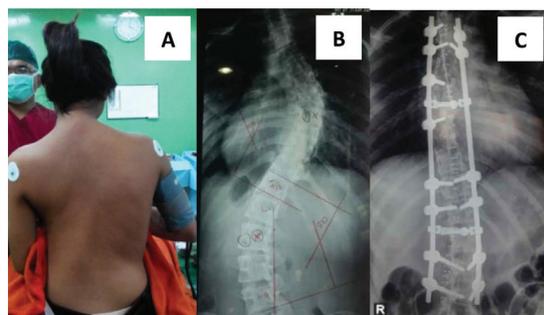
(A,B) Patient back view and plain X-ray of a female AIS patient shows a severe curvature producing right thoracic scoliosis, right shoulder elevation, scapula prominence and ribs adjacent to the convexity; (C) Instrumentation of thoracolumbar spine with fusion using pedicle screw-rod system and using autologous iliac graft with acceptable correction
